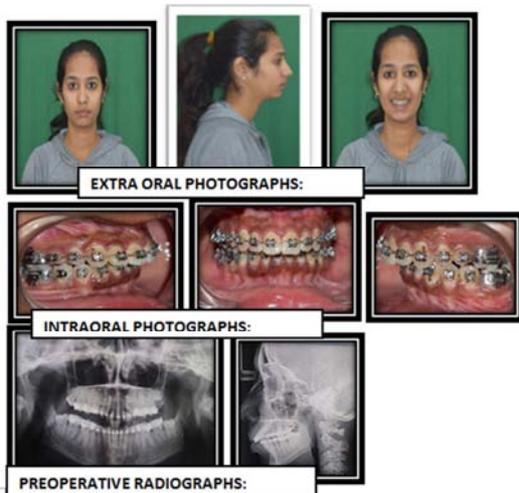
Extraoral photograph-front view lateral view; intraoral photographs, preoperative radiograph- OPG, Lateral cephalogram.
